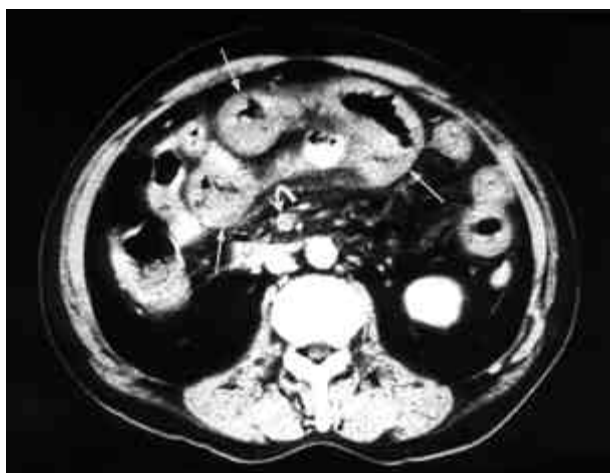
Bowel infarct due to superior mesenteric venous thrombosis. Contrast-enhanced CT shows diffuse bowel wall thickening (straight arrows) of the jejunum along with a thrombus (curved arrow) in the superior mesenteric vein. Also noted are mesenteric vascular engorgement and haziness (From [27], with permission).
